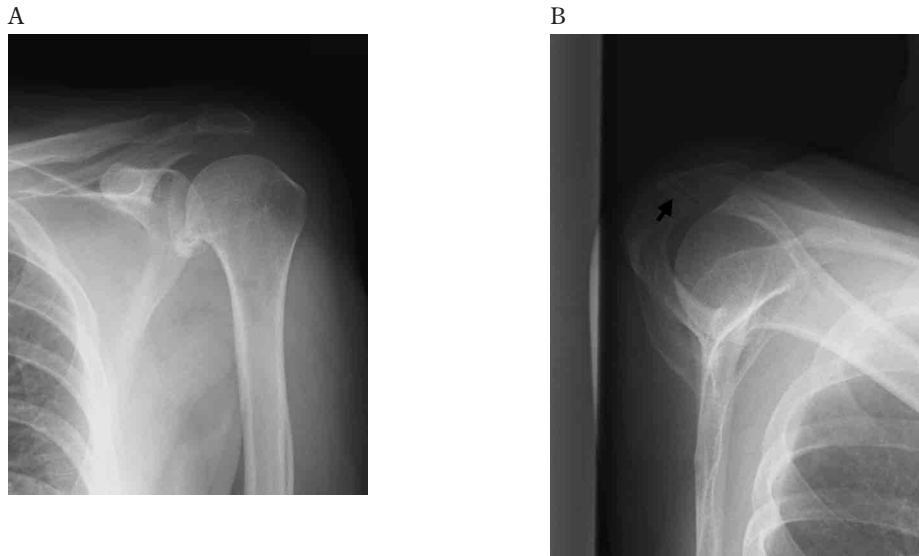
Plain radiographs of the left shoulder of an elderly patient with *os acromiale*. Mild degenerative arthritis is demonstrated on the anteroposterior view (A). Non-union between the meso-acromion and the meta-acromion (arrow) is noted on the scapular outlet view (B).
